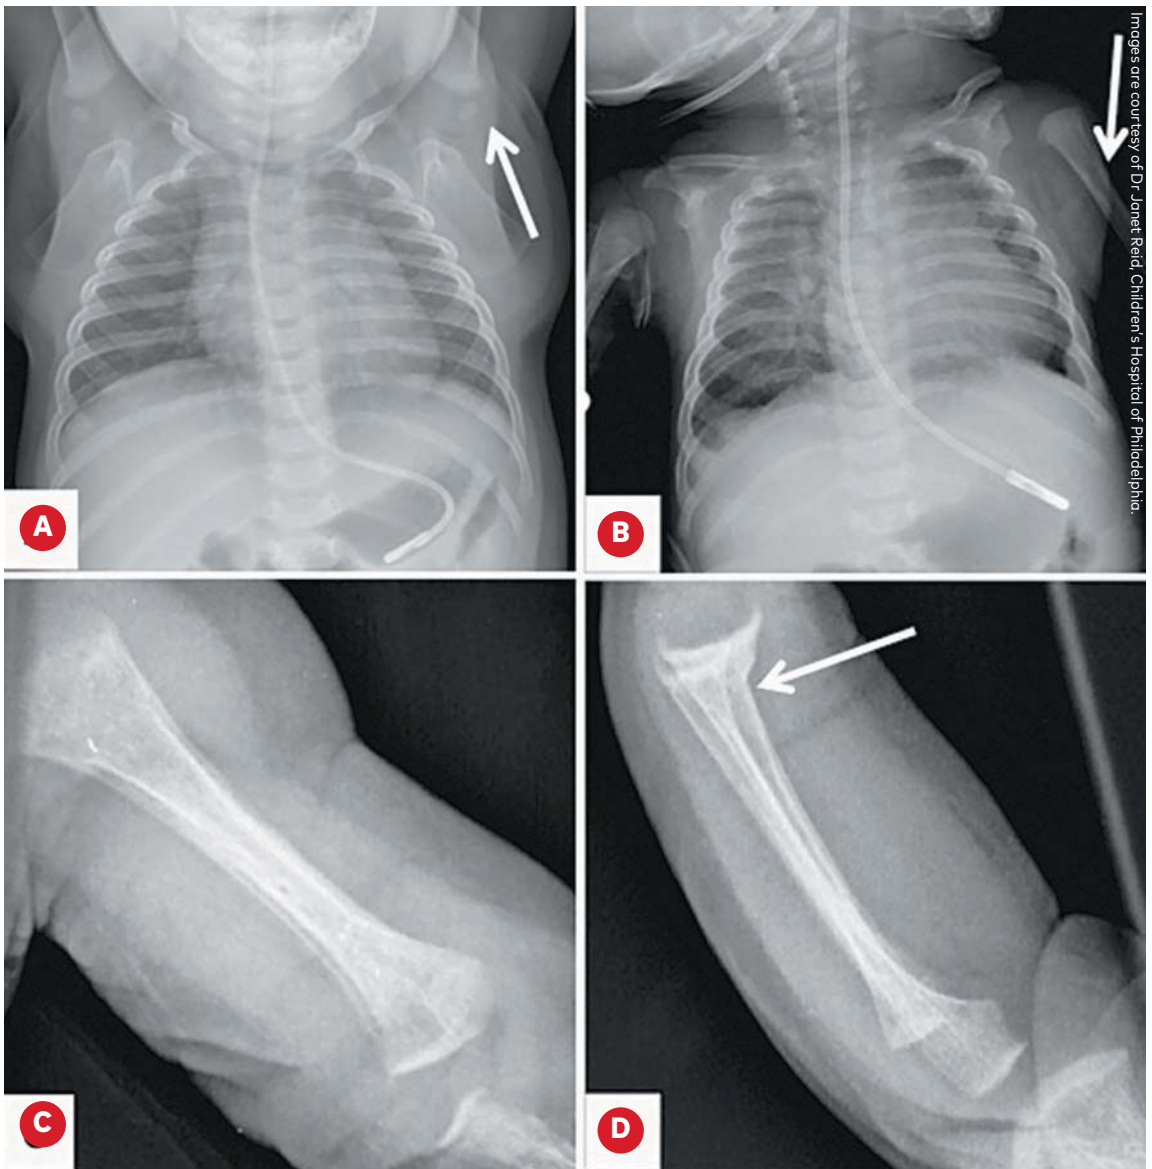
X-rays in metabolic bone disease of prematurity.
